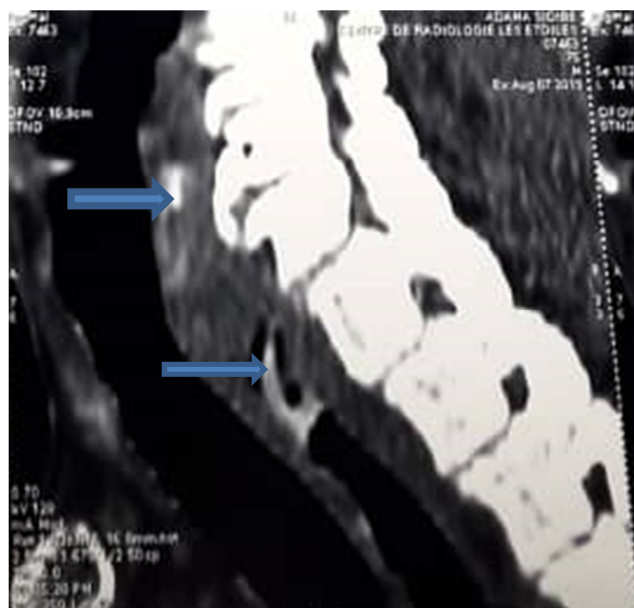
CT cervicothoracic in sagittal couples: highlighting the prosthesis enclosed in the Oesophageal lumen.
